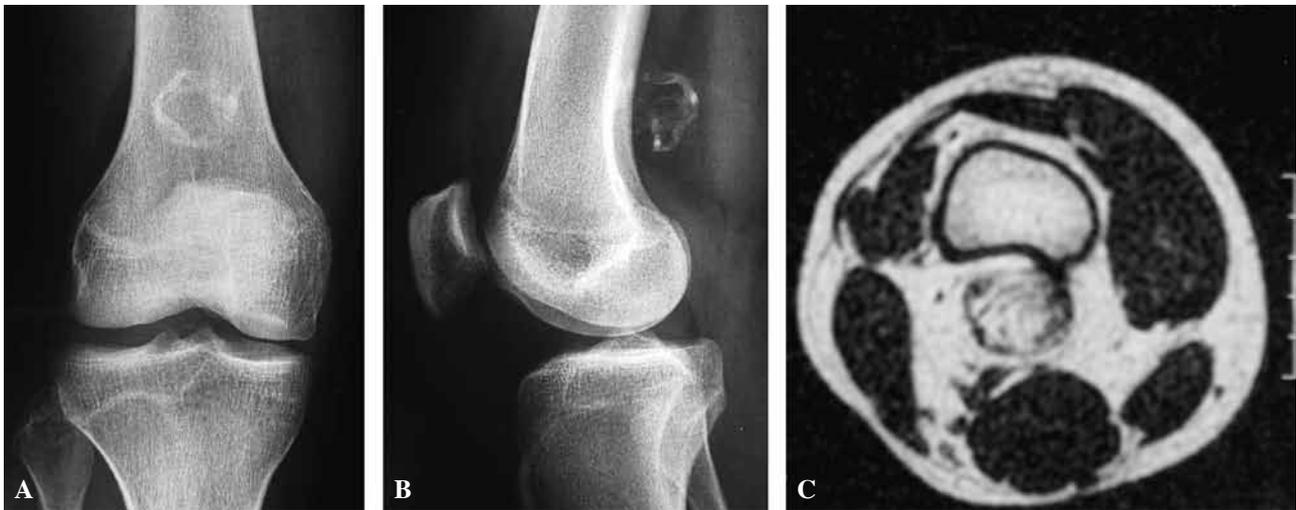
A & B : X-ray imaging revealed a calcification within the thigh mass which was denser peripherally than centrally. The image displayed a thin area of decreased opacity separating the mass from the femoral shaft. C : MRI disclosed a mass which was well delineated by a hypo intense zone representing the mineralized component. The signal intensity from the mass core was heterogeneous.
